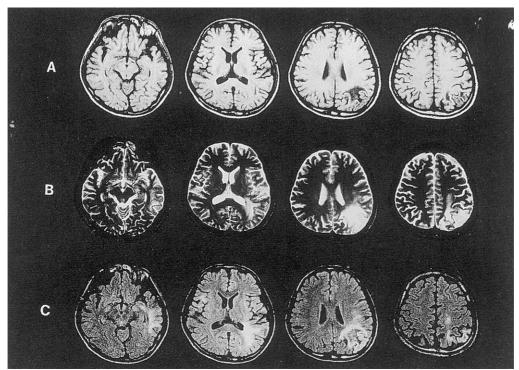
MR images of the brain on March 4, 1996. The lesions involve mainly the subcortical structures in the parietal and temporal lobes, but also the gray matter of the parietal cortex. A small hyperintense area in the right frontoparietal operculum is also visualized in B and C. A: T1-weighted images (TR: 600 milliseconds, TE: 16 milliseconds), B: T2-weighted images (TR: 4500 milliseconds, TE: 100 milliseconds), C: FLAIR images (TR: 6500 milliseconds, TI: 2000 milliseconds, TE: 100 milliseconds).
